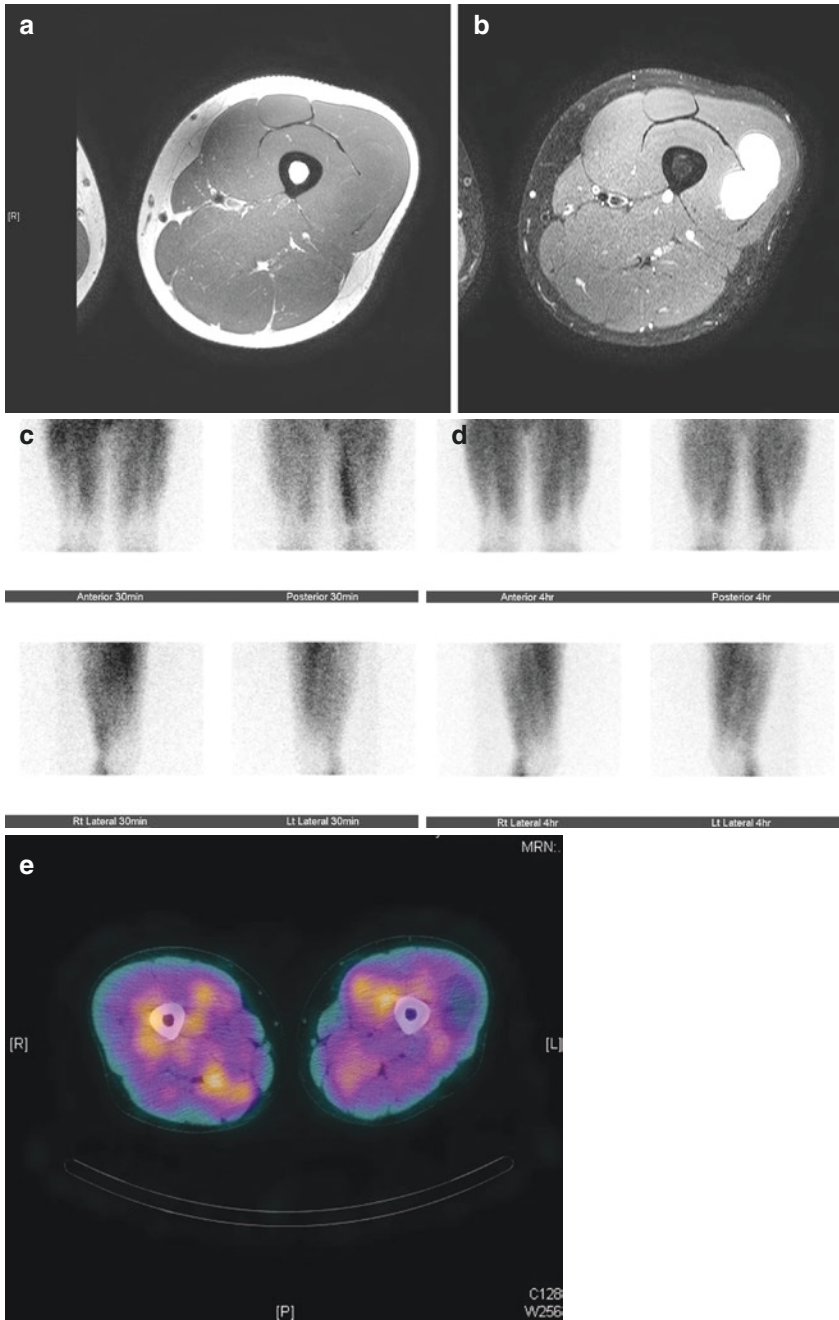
(a) A 26-year-old male presents with a painless mass involving the lateral aspect of the left thigh. MRI T1 axial image demonstrates an isointense mass in the left vastus lateralis. (b) T2-weighted image shows high signal within the mass consistent with a myxoid lesion. (c) Early (30 min) and (d) delayed (4 h) planar Tl-201 images showing no appreciable uptake within the mass. (e) Delayed SPECT/CT Tl-201 axial image confirming the lesion appears photopaenic with no appreciable retention of tracer. Percutaneous biopsy demonstrated myxoid liposarcoma
